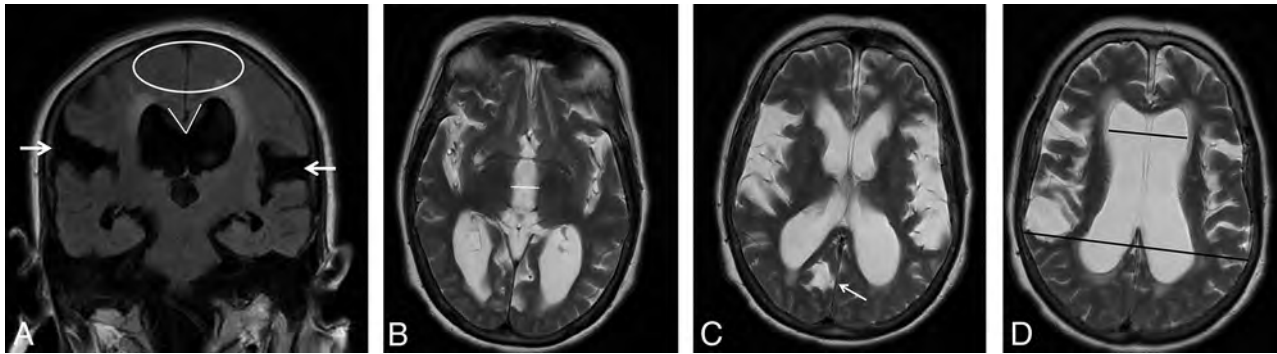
MR imaging of a 79-year-old female shunt-responder with an NPH Radscale score of 11. A, Coronal FLAIR image shows marked bilateral Sylvian fissure dilation (*white arrows*), apical narrowing of sulci (*white ellipse*), a narrow CA (65°), and marked periventricular hyperintensities. B–D, Axial T2 images at different levels show measurement of third ventricle diameter (*white line*), sulcal dilation (*white arrow*), and measurements used for the Evans ratio calculation (*black lines*).
